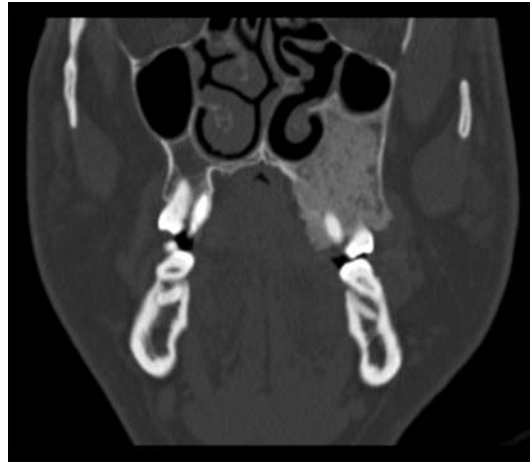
Fibrous dysplasia: Fibrous dysplasia presenting as an ill-defined expansion of the left maxilla with homogenous ground-glass appearance (CT scan, coronal plane).
